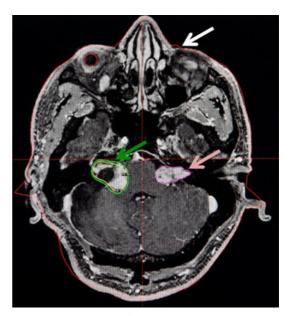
Steps of planning; T1 MRI image with 1 mm thickness obtained days before the procedure fused to a CT on the day of the procedure with the patient having the stereotactic frame for definition of coordinates. The CT also provides the automatic contour of the patient's head; notice the white arrow showing the red line contouring the image, which defines the surface of the patient for calculation of beam attenuation. The tumour on the right of the figure demonstrated the segmentation of the lesion, which was contoured with the automatic tools of the software, determining the volume of the lesion (pink arrow). The green arrow demonstrates the multiple-isocentre-depicted isodoseline. It conforms to a partially removed acoustic neuroma in the neurofibromatosis patient. Notice the two lines, yellow and green, representing the 12 Gy and the 10 Gy lines, respectively. (See insert for colour representation of the figure.)
